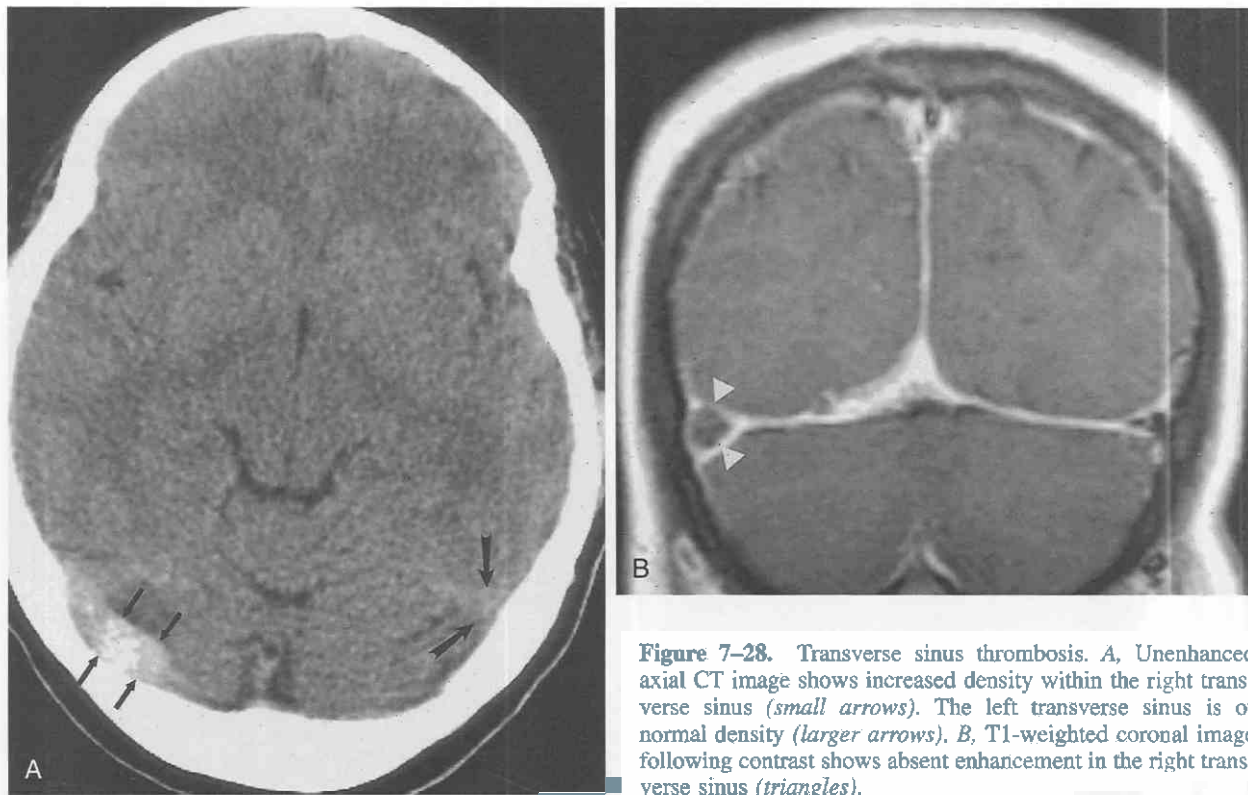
Transverse sinus thrombosis. *A*, Unenhanced axial CT image shows increased density within the right transverse sinus (*small arrows*). The left transverse sinus is of normal density (*larger arrows*). *B*, T1-weighted coronal image following contrast shows absent enhancement in the right transverse sinus (*triangles*).
